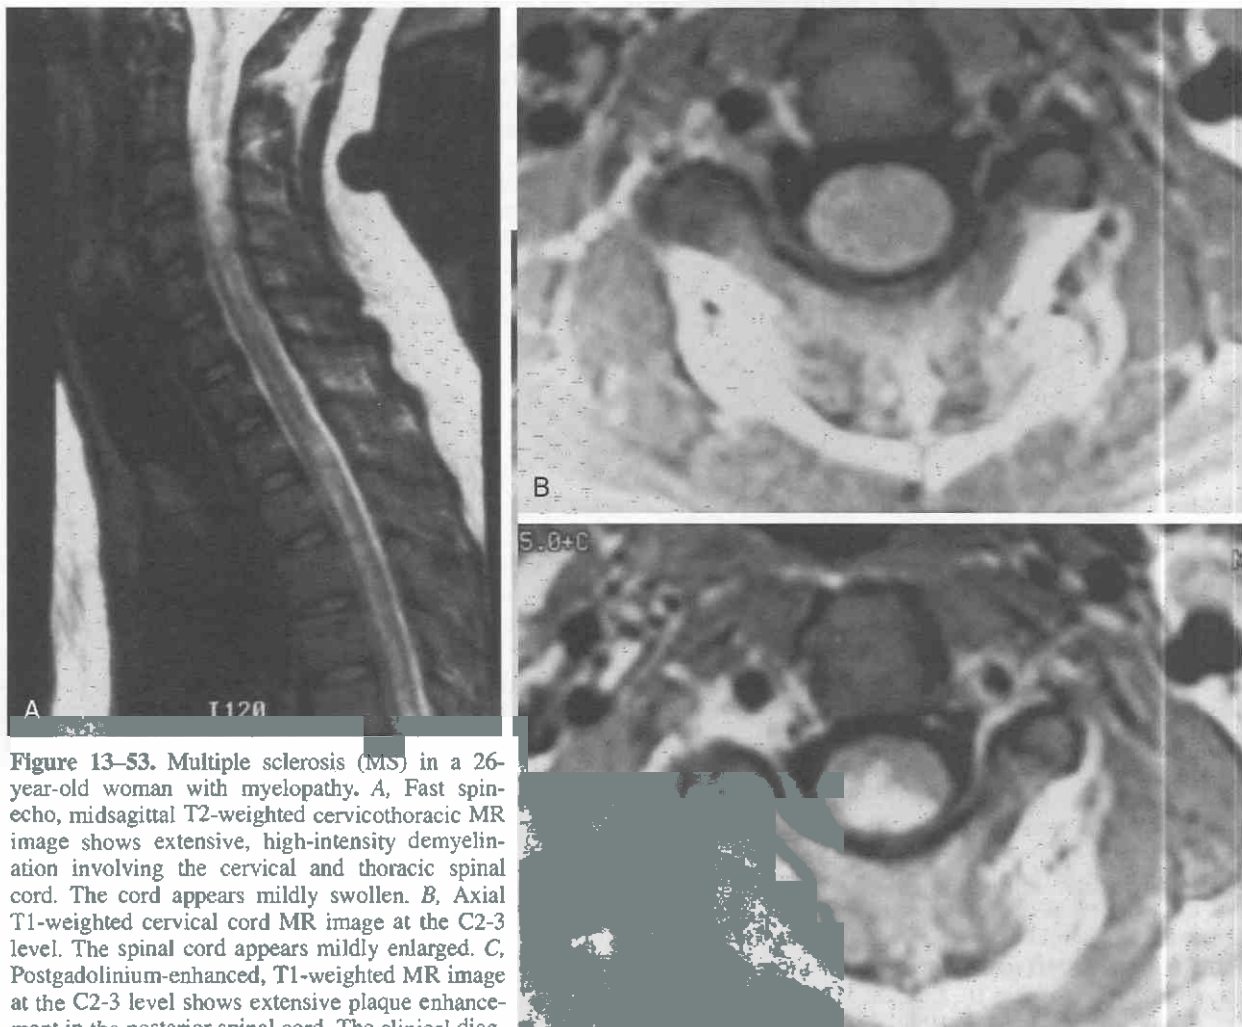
Multiple sclerosis (MS) in a 26-year-old woman with myelopathy. *A*, Fast spin-echo, midsagittal T2-weighted cervicothoracic MR image shows extensive, high-intensity demyelination involving the cervical and thoracic spinal cord. The cord appears mildly swollen. *B*, Axial T1-weighted cervical cord MR image at the C2-3 level. The spinal cord appears mildly enlarged. *C*, Postgadolinium-enhanced, T1-weighted MR image at the C2-3 level shows extensive plaque enhancement in the posterior spinal cord. The clinical diagnosis is MS.
